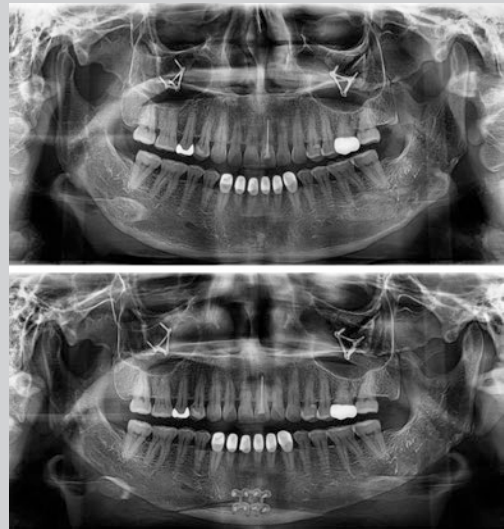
Preoperative and postoperative panoramic radiograph of a 28-year-old female. The mandibular angles were reduced during the prior surgery. The remaining broadness in the chin region was further reduced by an additional mini V-line surgery
